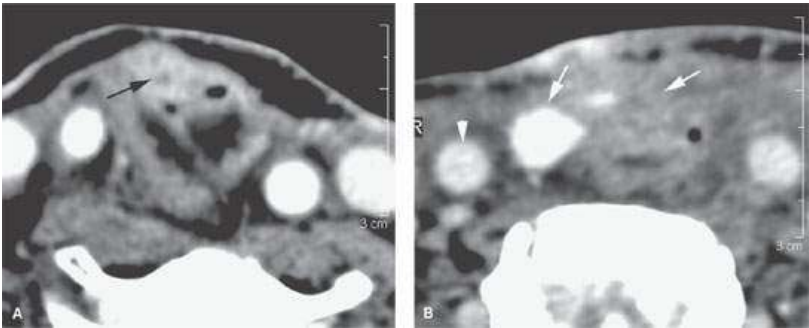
A patient with T3 glottic carcinoma. A contrast-enhanced computed tomography study was done. A: Right true vocal cord cancer with thickening of the anterior commissure (arrow) and sclerosis of the arytenoid cartilage and superior margin of the cricoid cartilage (arrowheads). B: The patient had approximately 12 mm of subglottic spread. The section through the lower subglottis shows the endoluminal tumor (arrow) and sclerosis of the adjacent cricoid cartilage. (NOTE: Tumor volume was slightly .3.5 cc; that combined with two sclerotic cartilages made this tumor high risk to fail radiotherapy [RT]. The patient elected for RT. Chemotherapy was also given. Treatment failed, and the patient was successfully salvaged with total laryngectomy, with the early failure picked up by surveillance anatomic imaging [not shown]).
